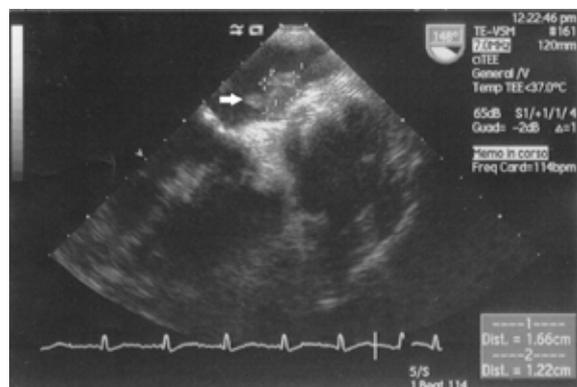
Transesophageal echocardiography showing vegetations in relation to the Amplatzer device
